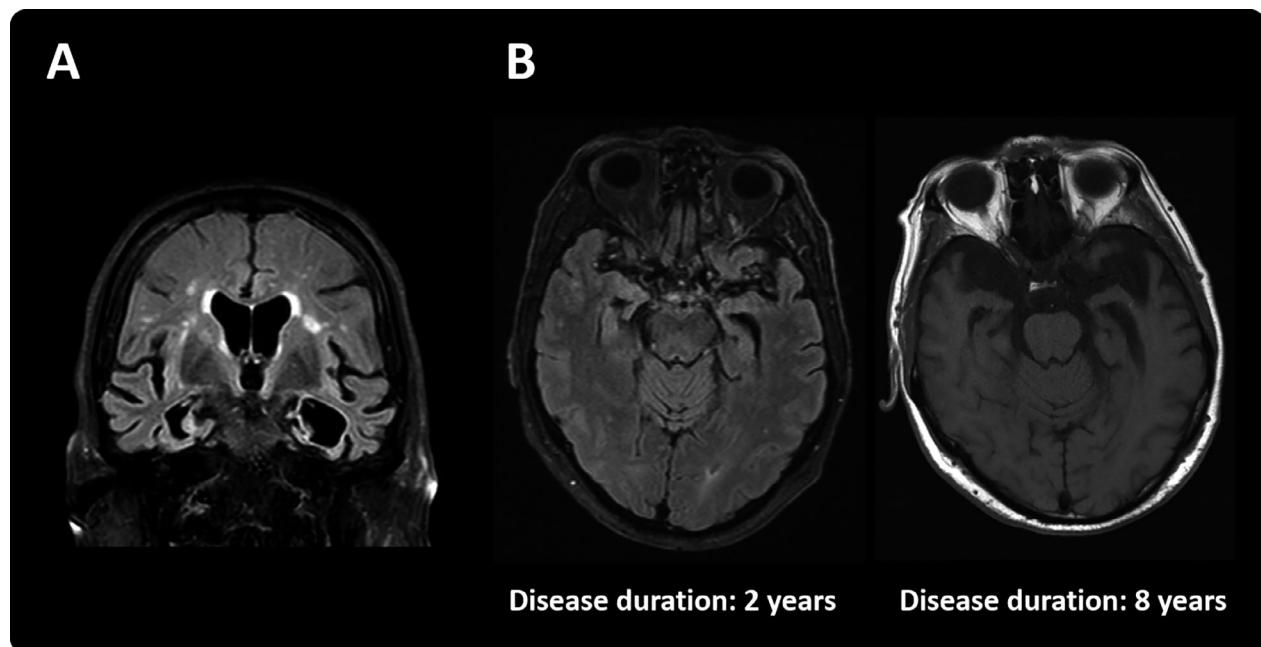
MRI of subject III.II.VI showing important medial and polar bitemporal atrophy (A). Longitudinal MRI examinations of subject II.II.IX (B).
